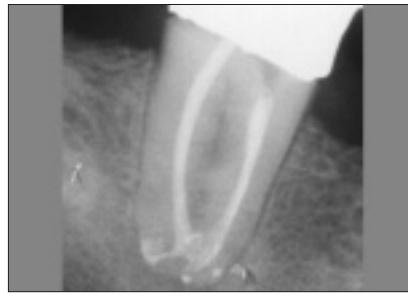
Radiograph taken 6 months after treatment shows total osseous fill-in. The apical complexities are completely sealed as indicated by the stable sealer puff.
